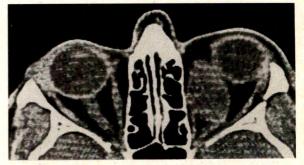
(Byrne, van Heuven, and Lawton). Case 1. Axial computed tomographic scan performed with contrast media displays mass in the superonasal aspect of the right orbit.
